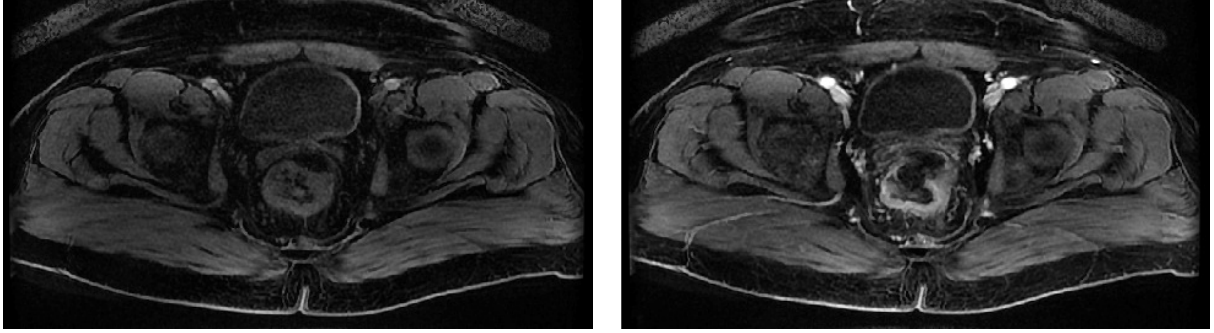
A slice from a DCE-MRI volume before the injection of contrast (left) and after contrast arrival (right). The brighter parts of the right-hand side image indicate the presence of contrast agent.
